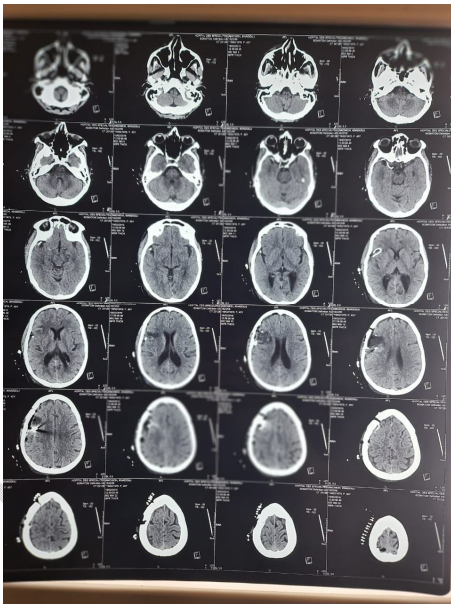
Postoperative cerebral CT of an excision of a right frontal AVM operated 24 hours after embolization
